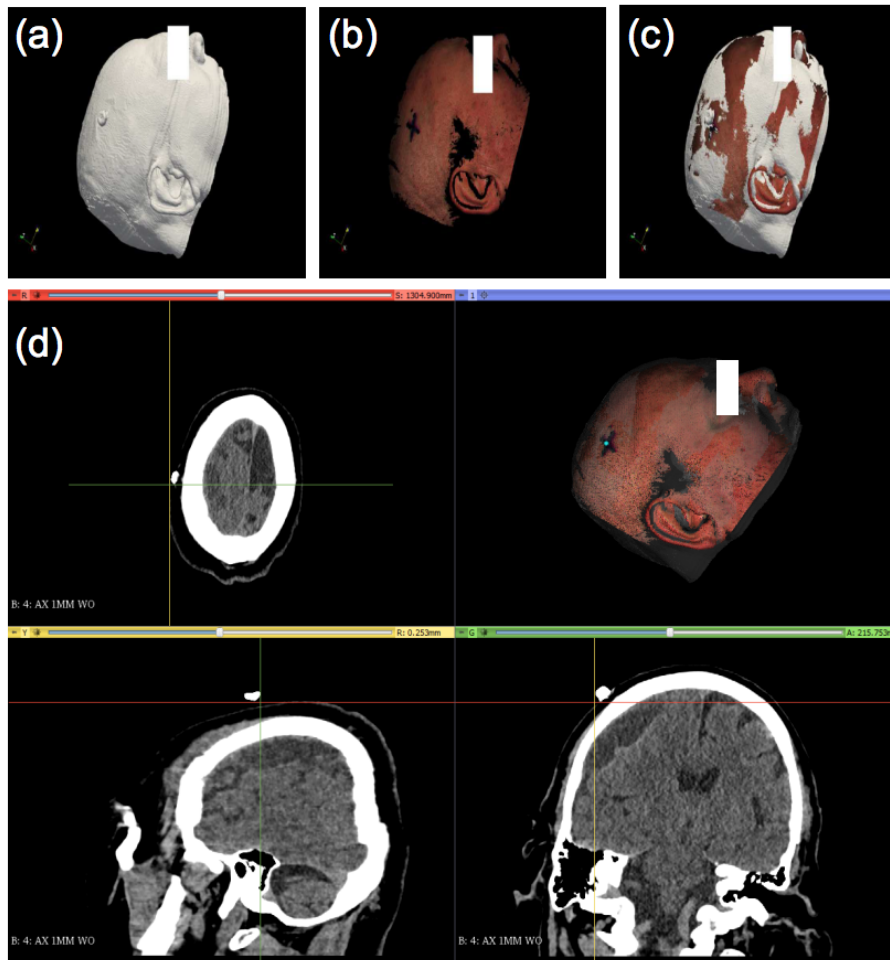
Evaluation of the 3D navigation system involving a patient with a CSDH who underwent SEPS placement. (a) 3-dimensional reconstruction of the patient's head from a pre-procedure CT scan. For this particular patient, a fiducial consisting of a metal hex nut was taped on the patient's head for the pre-procedure localizing CT scan. The initial CT scan obtained on patient presentation had too much movement and could not be used either for surgical procedure planning or for this project. The patient's eyes have been obscured for anonymity. (b) A color 3-dimensional scan of the patient's head with an "X" marking the proposed burr hole location. The proposed location is posterior and lateral to the hex nut's location, due to the recognition that the hex nut's location is too anterior and superior. (c) Registration between the CT scan and the visible light-based 3D scan of the patient. Beige areas are where the 3D scan surface is closer to the observer, and white areas are where the CT scan is closer to the observer. As expected, the "X" mark is posterior and lateral to the fiducial. (d) Navigation panel generated by the system. All views are aligned at the center of the "X" mark. The top left is the axial view of the patient's CT scan, top right is the alignment between the 3D scan and the CT scan, bottom left is the sagittal view, and bottom right is the coronal view. Cross hairs indicate the center of the ink "X" mark on the 3D scan. All of the panels are scrollable.
